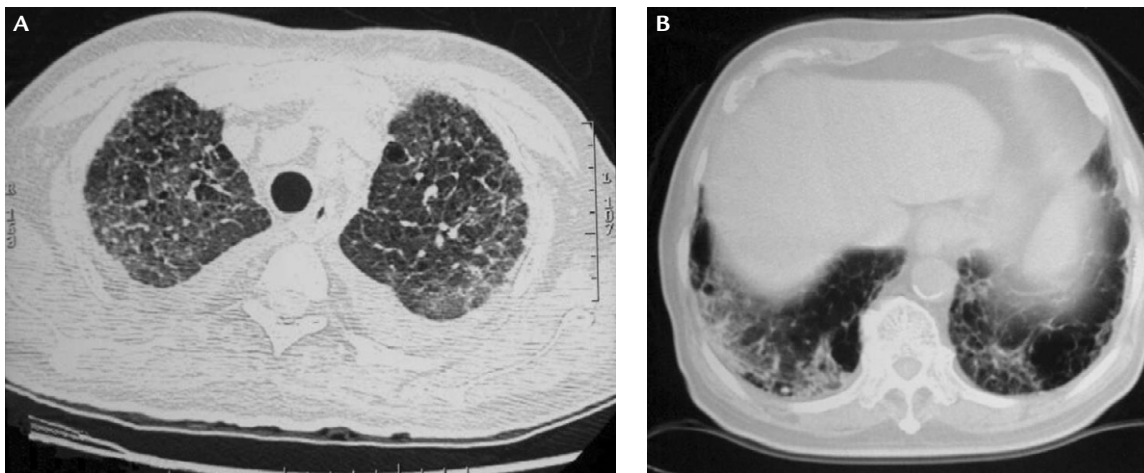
(A) Chest computed tomography (CT) of patient 1 (with contrast medium, lung window) obtained on admission shows multiple interstitial infiltrations. (B) Chest CT of patient 3 (without contrast medium, lung window) obtained on admission shows fibrotic patches with honeycomb appearance in both lungs.
